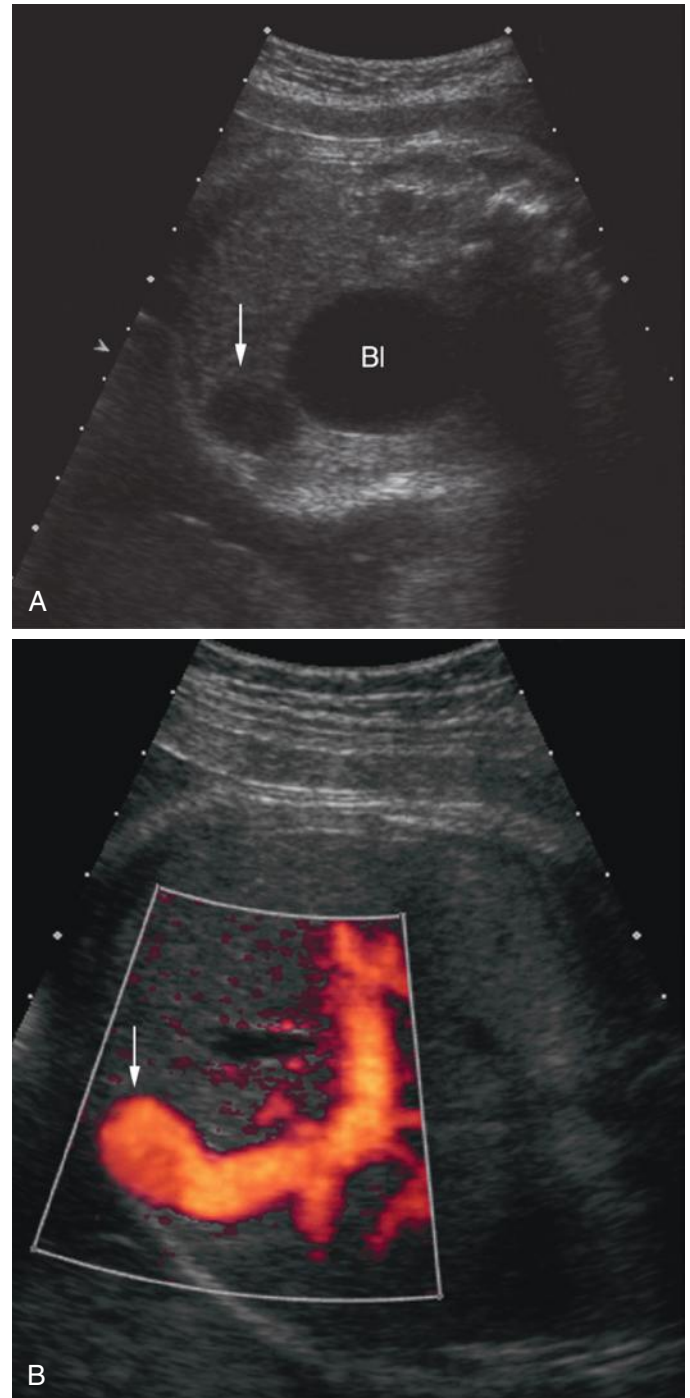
Umbilical vein varix. Initially it was thought that the prognosis in cases of umbilical vein varix was uniformly poor. However, if there are no associated abnormalities, most cases do well. A, Umbilical vein varix (*arrow*) seen adjacent to the anterior abdominal wall and the urinary bladder (Bl). B, Color Doppler imaging of an umbilical vein varix (*arrow*). In neither case were there associated abnormalities, and the outcomes were normal in both cases.
